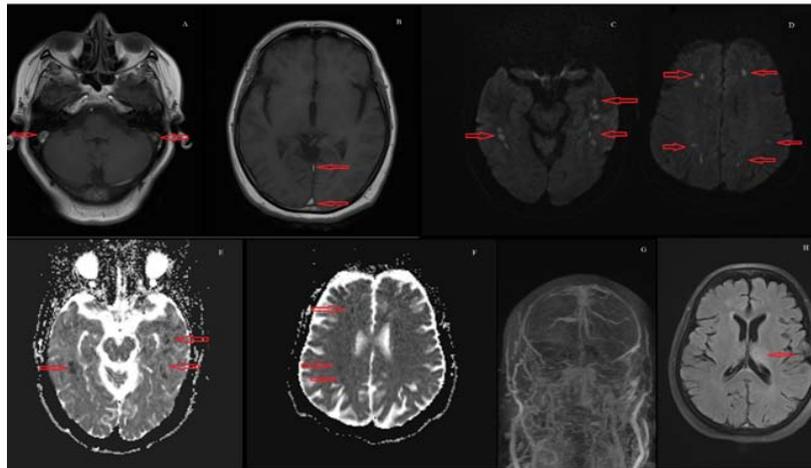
In the second case, brain MRI revealed in T1 sequence an appearance compatible with hyperintense thrombus in bilateral transverse sinus (A), straight sinus and superior sagittal sinus (B). Watershed infarct areas with bilateral diffusion restriction were observed on DWI (C-F). Contrast-enhanced MRV revealed filling defect in all superficial and deep veins (G) and hyperintense swelling in the left thalamus in FLAIR sequence (H).
